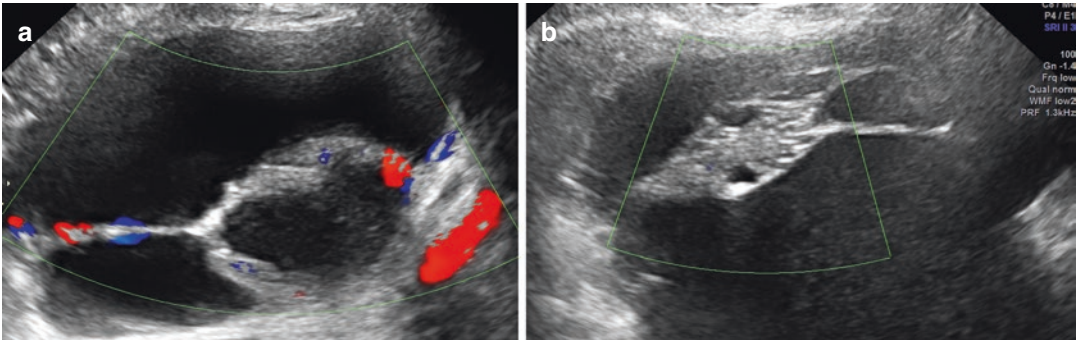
Ultrasound images of peritoneal pseudocysts. (a) A gray-scale image showing thick, irregular septations which are poorly vascularized on color Doppler. (b) An image of normal ovary suspended within the pseudocyst
